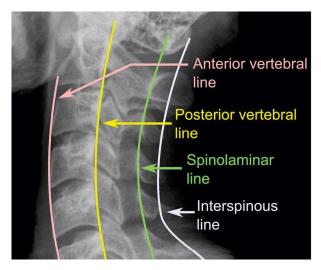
The "lines" of the cervical spine. (From https://upload.wikimedia.org/wikipedia/commons/1/10/X-ray_of_vertebral_lines.jpg)
